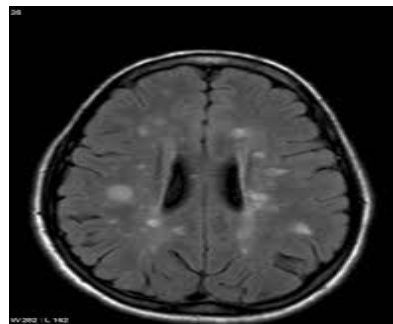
MRI brain Axial section showing periventricular white matter intensities
